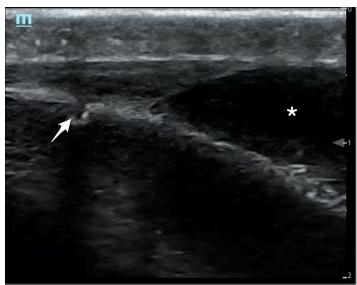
Point-of-care ultrasound demonstrating a cephalohematoma (*) that does not cross over the suture line (arrow).
